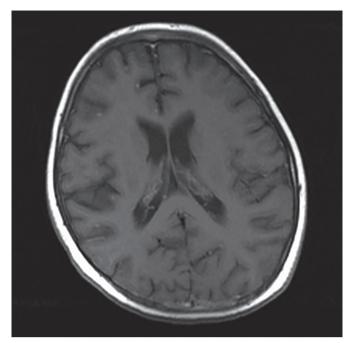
Contrast enhanced T1-weighed magnetic resonance imaging scan showing nodular parenchymal lesions.
